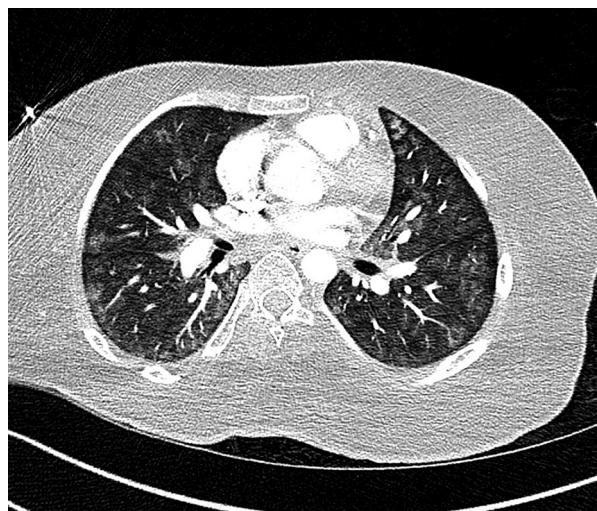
Computed tomography scan of the chest demonstrating ground glass opacities.
